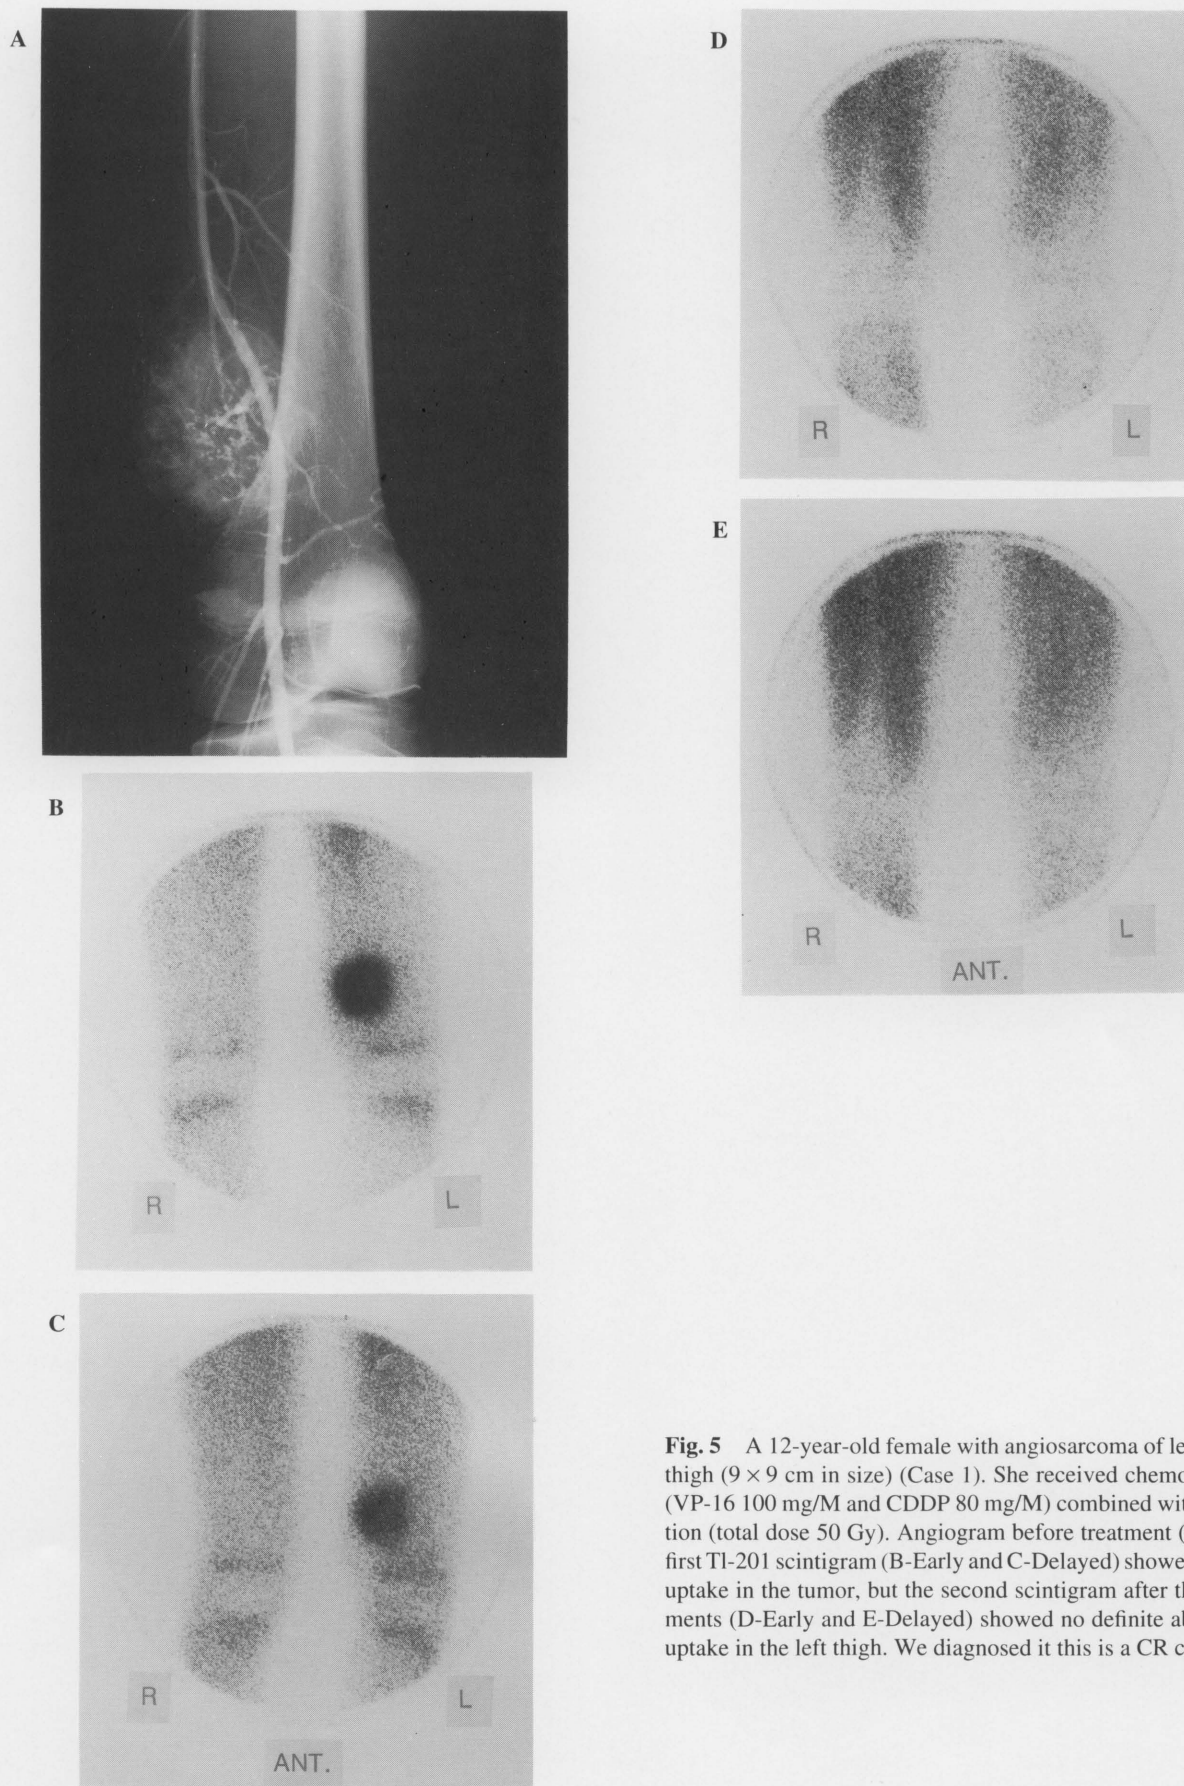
A 12-year-old female with angiosarcoma of left lower thigh (9×9 cm in size) (Case 1). She received chemotherapy (VP-16 100 mg/M and CDDP 80 mg/M) combined with radiation (total dose 50 Gy). Angiogram before treatment (A). The first Tl-201 scintigram (B-Early and C-Delayed) showed strong uptake in the tumor, but the second scintigram after the treatments (D-Early and E-Delayed) showed no definite abnormal uptake in the left thigh. We diagnosed it this is a CR case.
